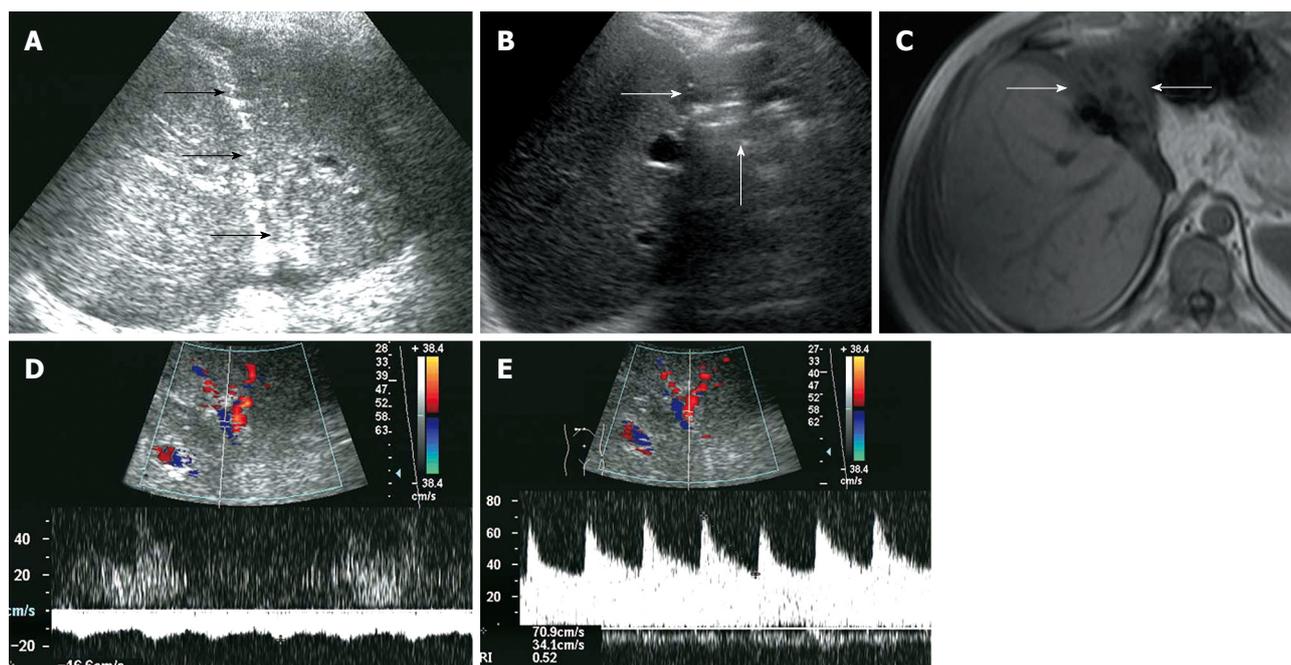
A 37-year-old man with a shrunken left graft after dual-graft liver transplantation. A: Gray scale sonogram shows the left graft (arrows) on postoperative day one; B and C: Size of the left graft decreased on follow-up sonogram and magnetic resonance imaging (arrows); D: Doppler spectrum shows the hepatofugal flow of the portal vein of left graft; E: Doppler spectrum shows the normal left hepatic artery.
